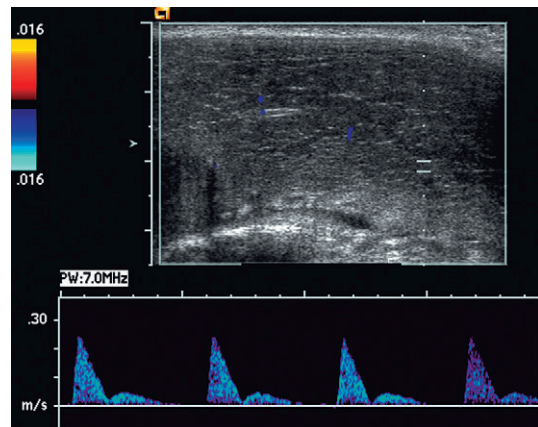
Spectral Doppler tracing in the early tumescent phase. Systolic waveform is narrowed into a sharp spike. Diastolic velocity decreases and a dichrotic notch are present in early diastole (arrow).
